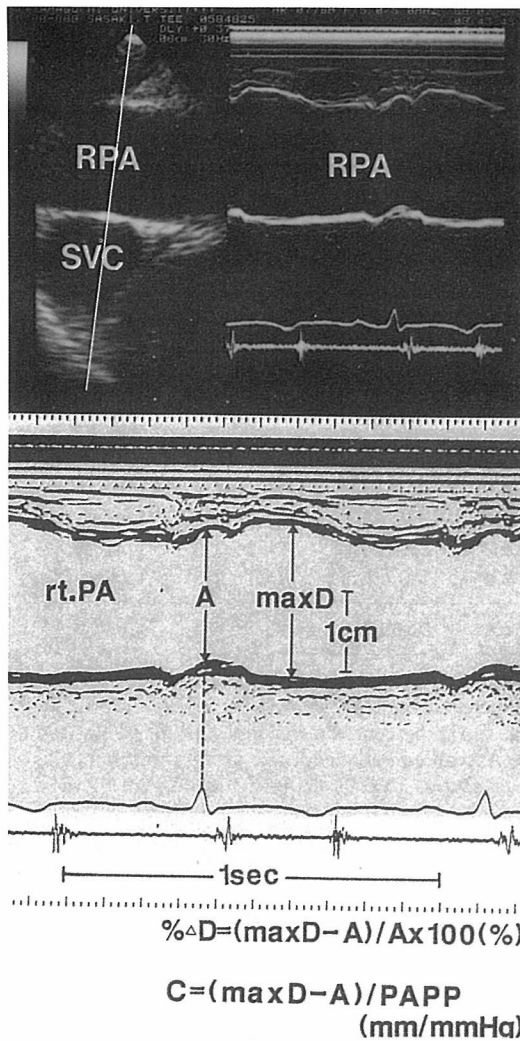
Transesophageal 2-dimensional and M-mode echograms of right pulmonary artery (upper panel), and measurements of dimensional changes (lower panel). RPA: right pulmonary artery, SVC: superior vena cava, maxD(mm): systolic maximum diameter of the right pulmonary artery, A(mm): end-diastolic diameter of the right pulmonary artery,  $\% \Delta D$  = percent dimensional change of the right pulmonary artery, C = compliance index, PAPP = pulmonary arterial pulse pressure.
